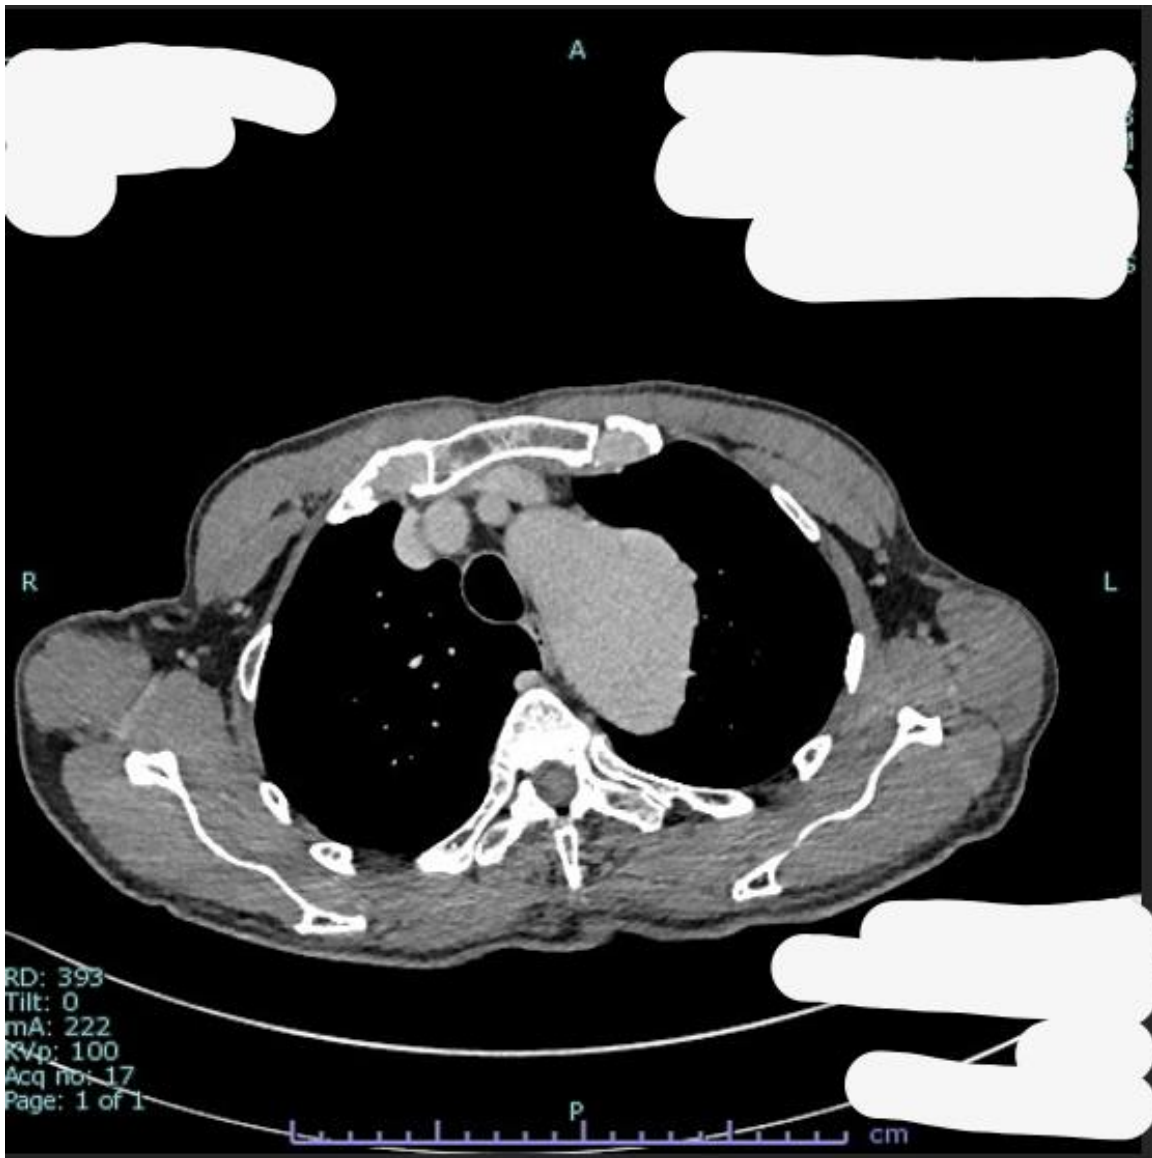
Axial view of CTA showing the pseudoaneurysm in the distal aortic arch.
